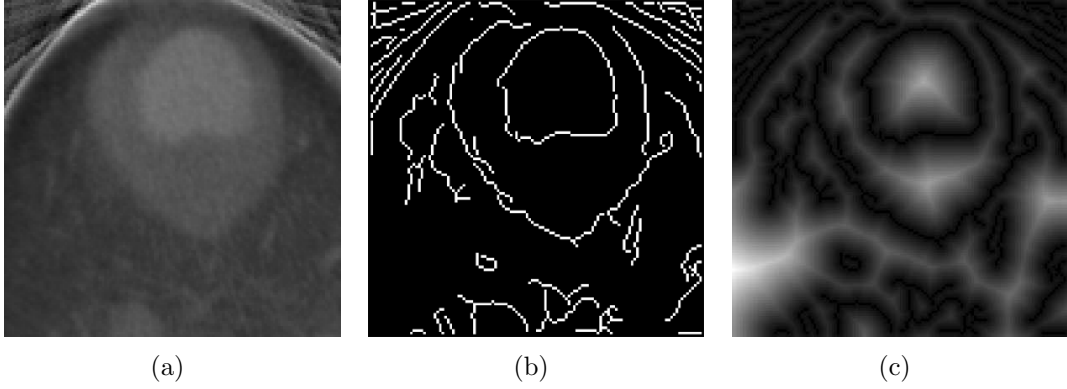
(a) A sample of CT cardiac image. (b) Edge detection result of the image. (c) Graph weighting map produced by applying distance transform on the edge map.
